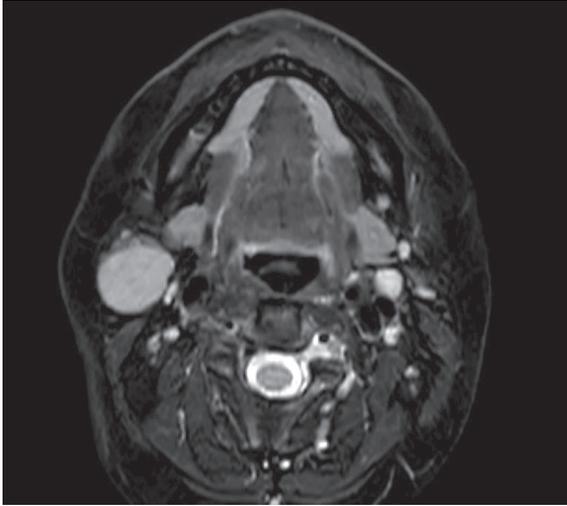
Axial magnetic resonance imaging view of the lesion in T2.
